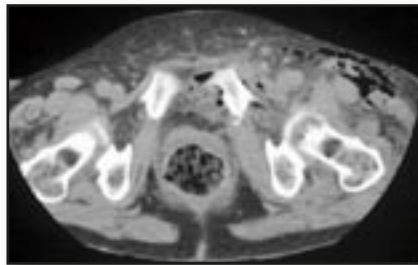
(patient 6). CT scan of the abdomen showing fluid and free intraperitoneal air near the fracture, which is suggestive of a gastrointestinal bowel perforation.
